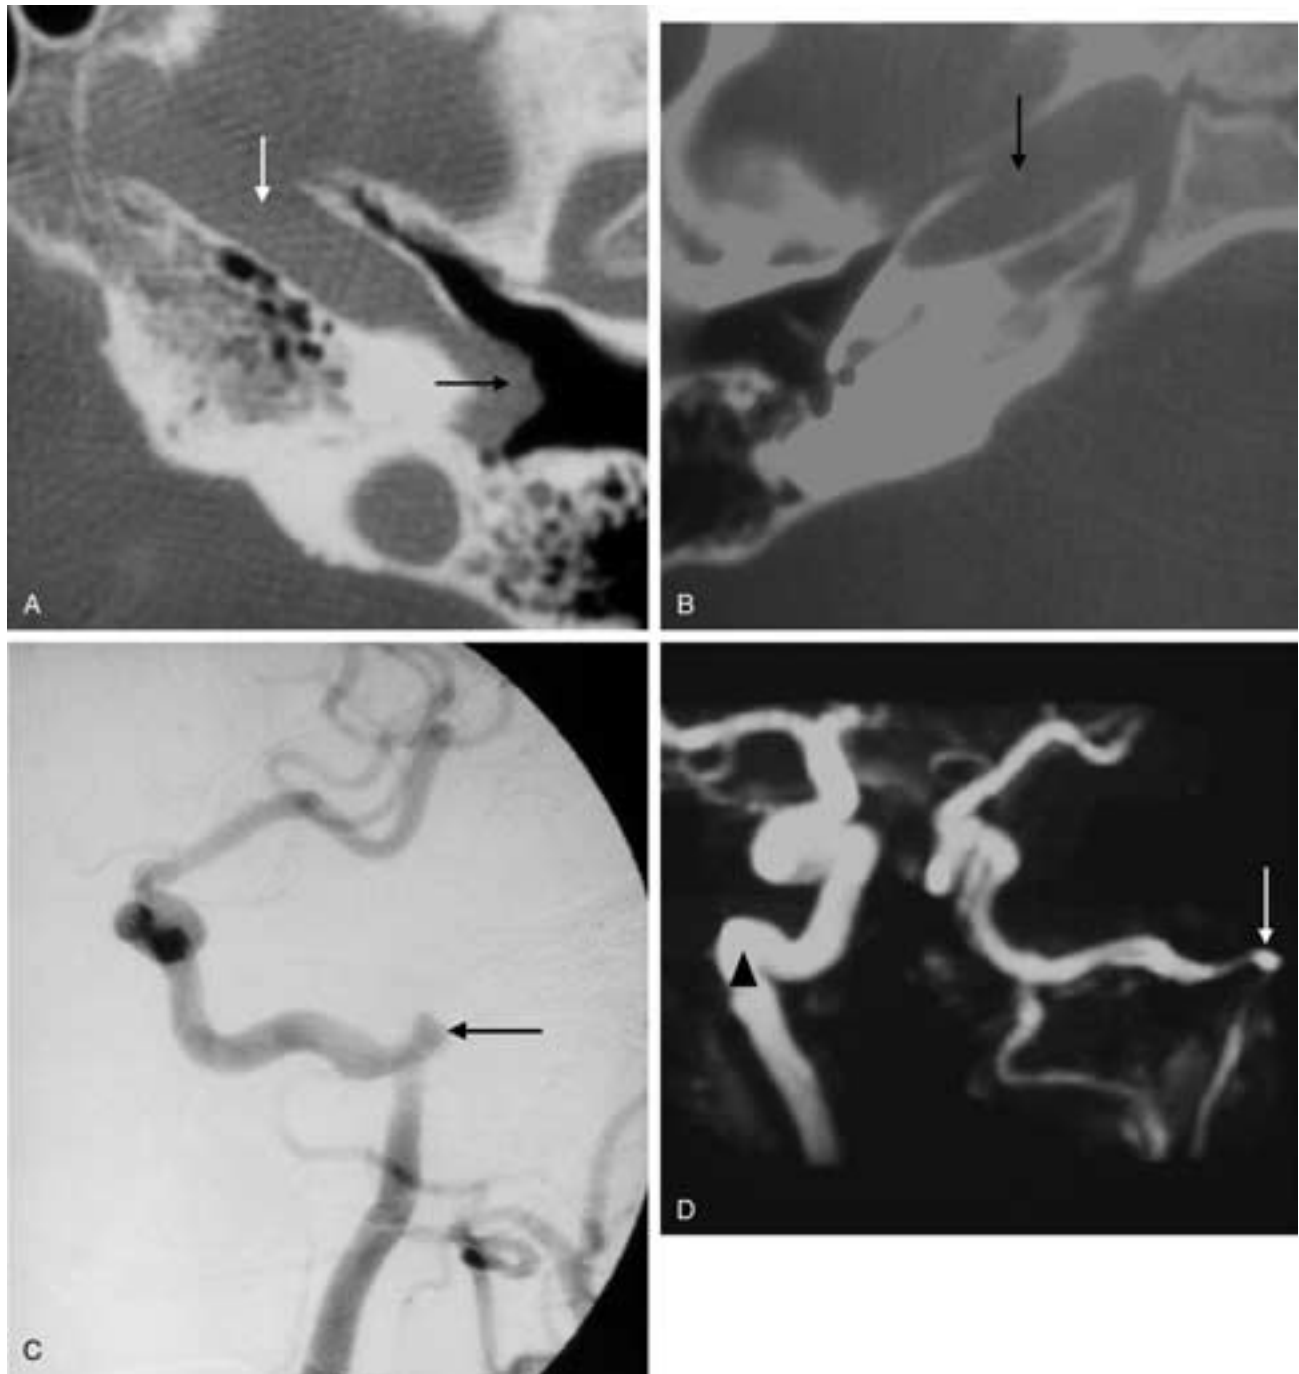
Aberrant ICA. A, Axial CT image showing an aberrant left ICA projecting into the left middle ear cavity (*black arrow*). Petrous carotid canal (*white arrow*). B, Axial CT image showing a normal right carotid canal (*black arrow*). C, Conventional digital subtraction angiography showing far lateral displacement of the left ICA (*black arrow*). D, MRA showing far lateral displacement of the left ICA (*white arrow*) and normal placement of the right ICA (*black arrowhead*).
